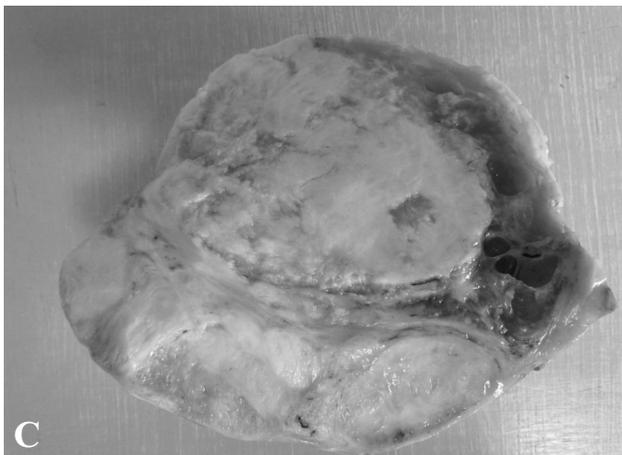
A) Coronal view of contrast CT revealing the voluminous tumor. B) Sagittal view of contrast CT reveals the tumor pushing the uterus and bladder forward. C) Macroscopic view of retroperitoneal mass.
